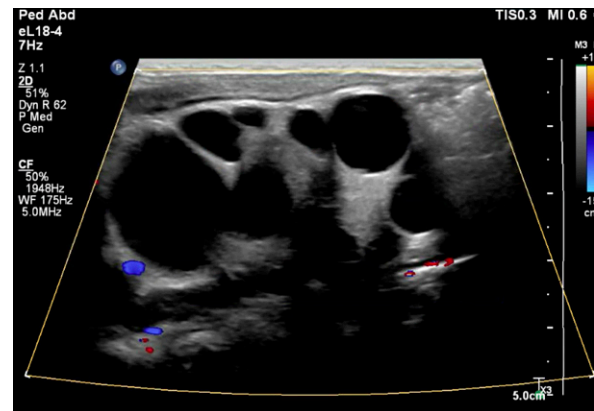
Postnatal ultrasound scan showing right multicystic dysplastic kidney.
